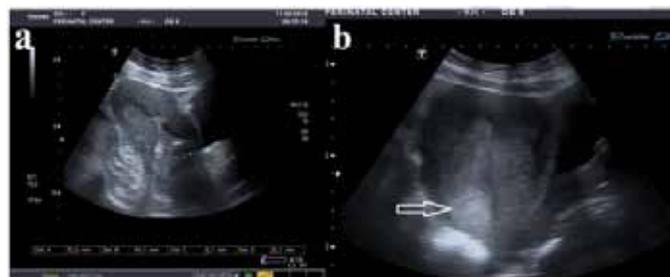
Ultrasound just before discharge of the patient from the Perinatal Center: (a) Absence of cervical contraction after D&C, (b) Heterogeneous tissue in the cervico-isthmic area (arrow).
